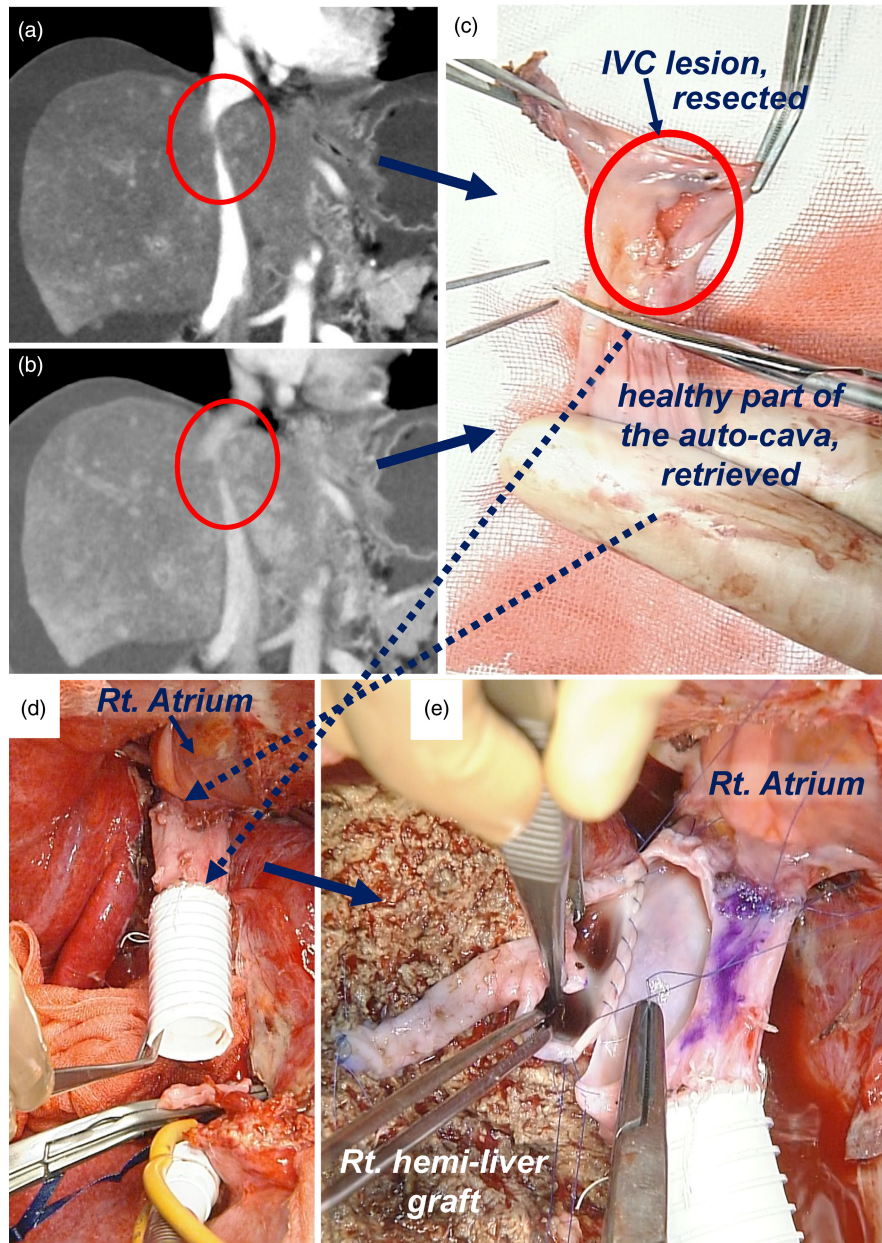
Pre- and intraoperative images of the IVC lesion and reconstruction. (a, b) Early/arterial and delayed/venous phases of coronal scan images, respectively, of the preoperative dynamic CT focusing on the IVC lesion. In this case, the IVC lesion was more clearly delineated in the early rather than delayed phases, but not enough to completely identify all the lesions. (c) A representative image showing IVC inspection from inside the vessel (lumen side). Under good direct vision on a back-table, the lesions, for example, obliterated, thrombosed, fibrotic, or even just thickened, can be easily and reliably identified. (d) An image representing IVC reconstruction using the harvested auto-IVC graft, corresponding to [Figure 1d](#). In this case, a ringed expanded polytetrafluoroethylene (ePTFE) graft was used for IVC interposition. (e) An image displaying HV anastomosis of a right hemi-liver graft to the auto-transplanted cava using continuous suture with 5-0 prolene. It is also important to open the IVC wide enough to create a large anastomotic orifice extending halfway around the right (graft) side. This procedure intrinsically reduces the potential risk of post-transplant BCS recurrence by using the autologous IVC that is confirmed healthy from both inside and outside the vessel. Furthermore, to ensure extra safety, the cranial and caudal ends of the harvested auto-IVC are reversed, and the originally caudal end, which is farthest from the BCS lesion and thus considered the healthiest, is anastomosed to the IVC root in the pericardium, that is, the most downstream anastomosis. The patient was discharged 3 weeks post-transplant with no surgical complications. She has been doing well for 2 years afterward with no BCS recurrence. BCS, Budd–Chiari syndrome; CT, computed tomography; HV, hepatic vein; IVC, inferior vena cava.
